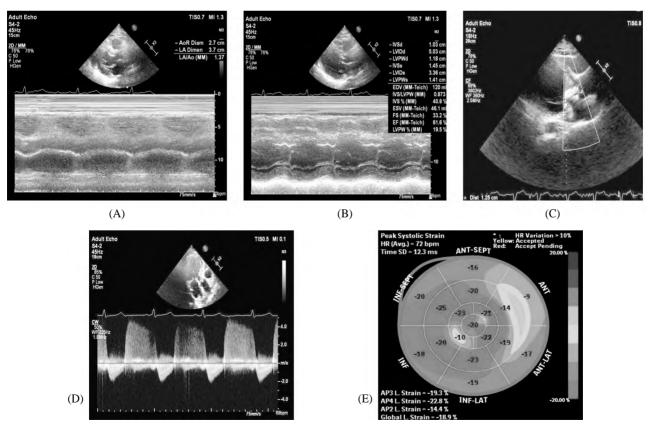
Forty-seven-year-old female with history of rheumatic heart disease. (A) M mode at AO and left atrium. (B) M mode at mid ventricular level to evaluate EF. (C) Color Doppler represents about >2/3 LVOT width. (D) CWD at AV. (E) Regional and global longitudinal strain.
